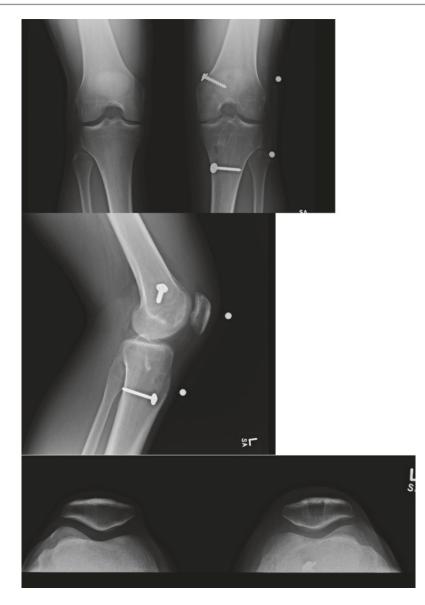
Post-operative X-rays depicting femoral and tibial fixation as wee as tunnel position and evidence of bone block harvest from the proximal patella
